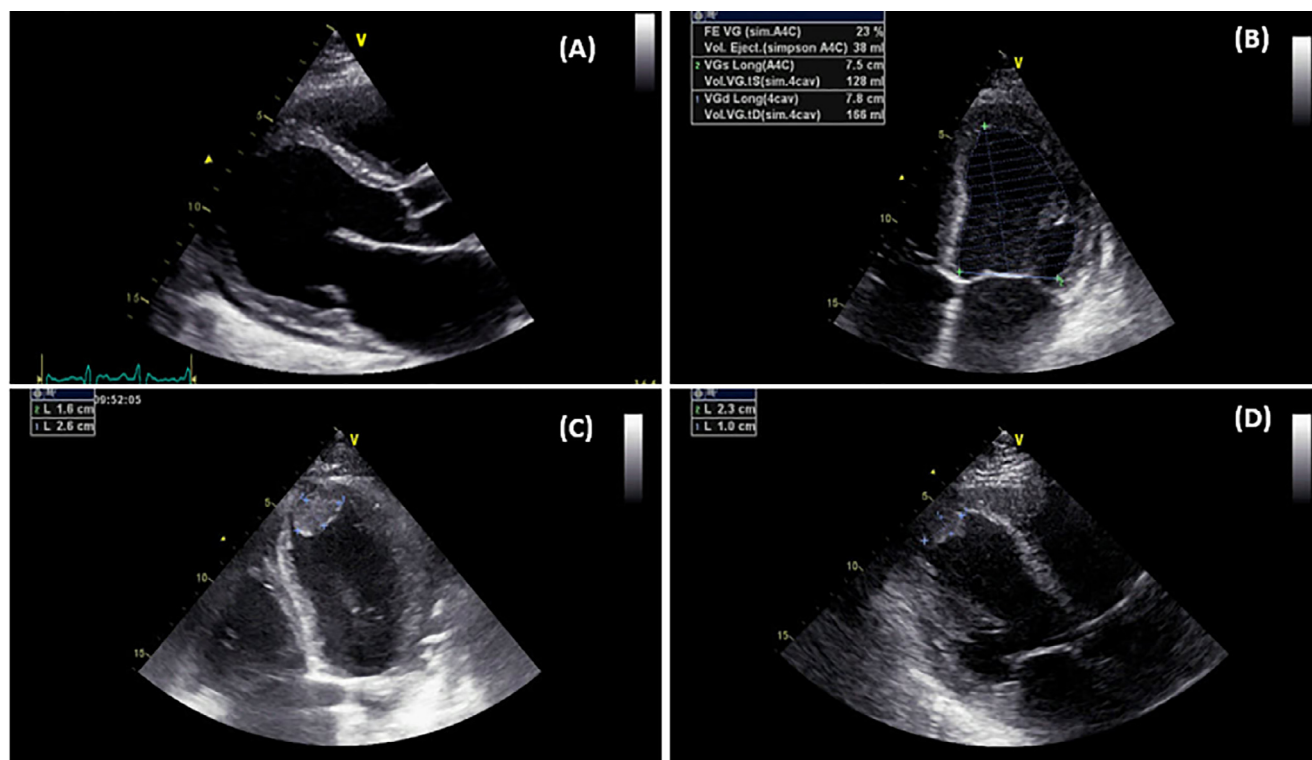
Echocardiogram showing (A) Small pericardial effusion with a significant biventricular enlargement (B) Markedly depressed left ventricular ejection fraction 23% (C) Left ventricular thrombus (D) Right ventricular thrombus.
